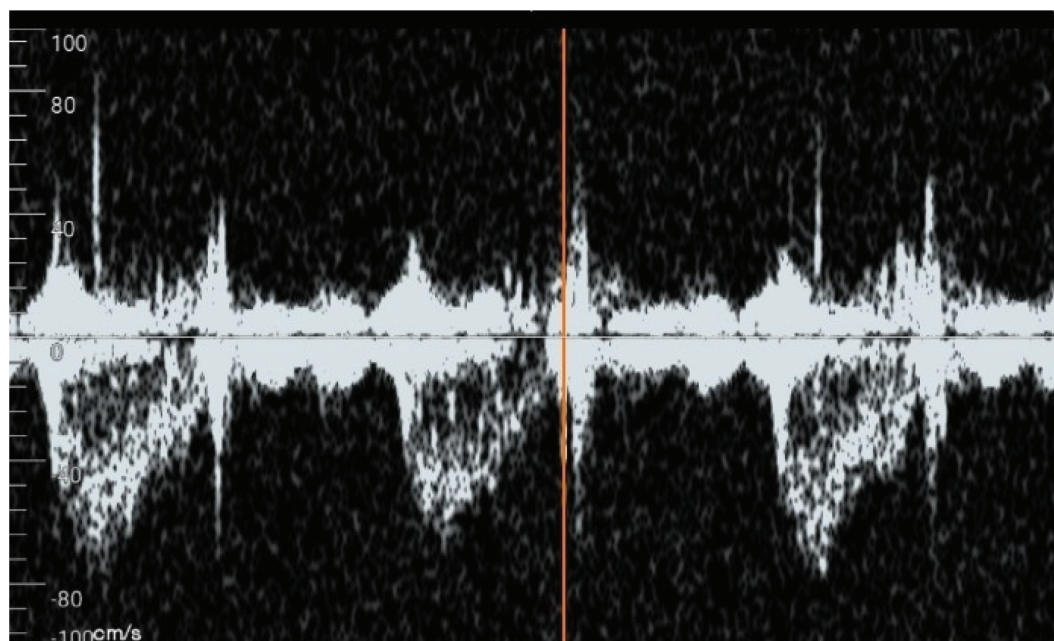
Right ventricular outflow tract Doppler at outpatient follow-up 6 weeks post-discharge showing much improved envelope.
